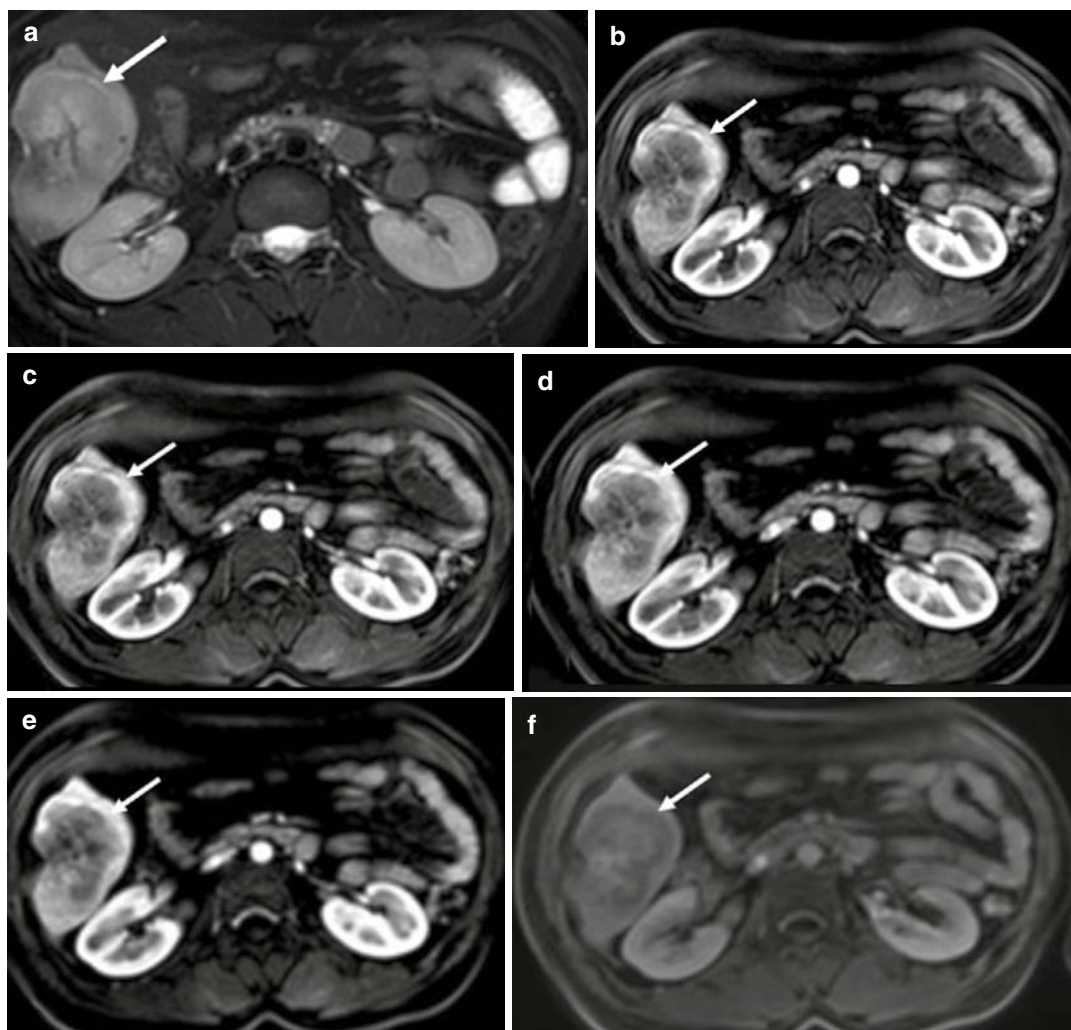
A 35-year-old male with intrahepatic cholangiocarcinoma. (a, b) Axial T2-weighted MRI (a) showed a well-defined, heterogeneous hyperintense mass in the liver (arrow) with diffusion restriction on high b-value (b=800) DWI (b). Overlying capsular retraction is seen.
